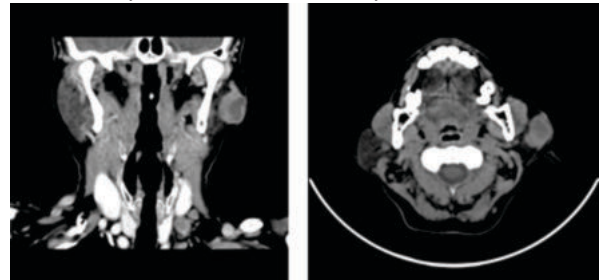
CT images show irregular soft tissue mass in left parotid gland with solid and cystic component.
